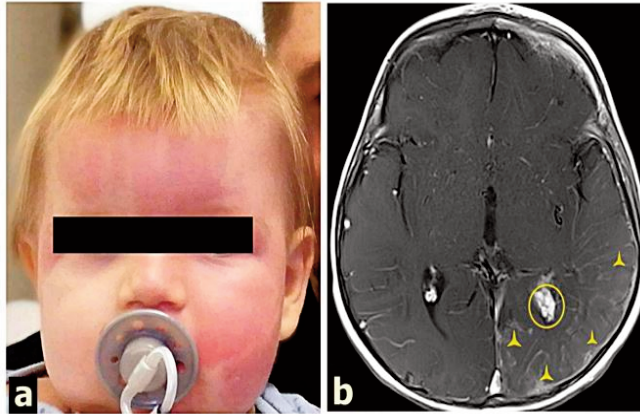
Clinical and radiological presentation of Sturge-Weber syndrome; called also encephalo-trigeminal angiomatosis. a : Child's face with a pathognomonic left sided facial birthmark related to capillary malformations in the regions of the forehead and left cheek .b: Axial T1+gadolinium MRI sequence of the same patient showing a hypertrophic choroid plexus (yellow circle) and multiples enhancements in sulci (yellow arrow head).
